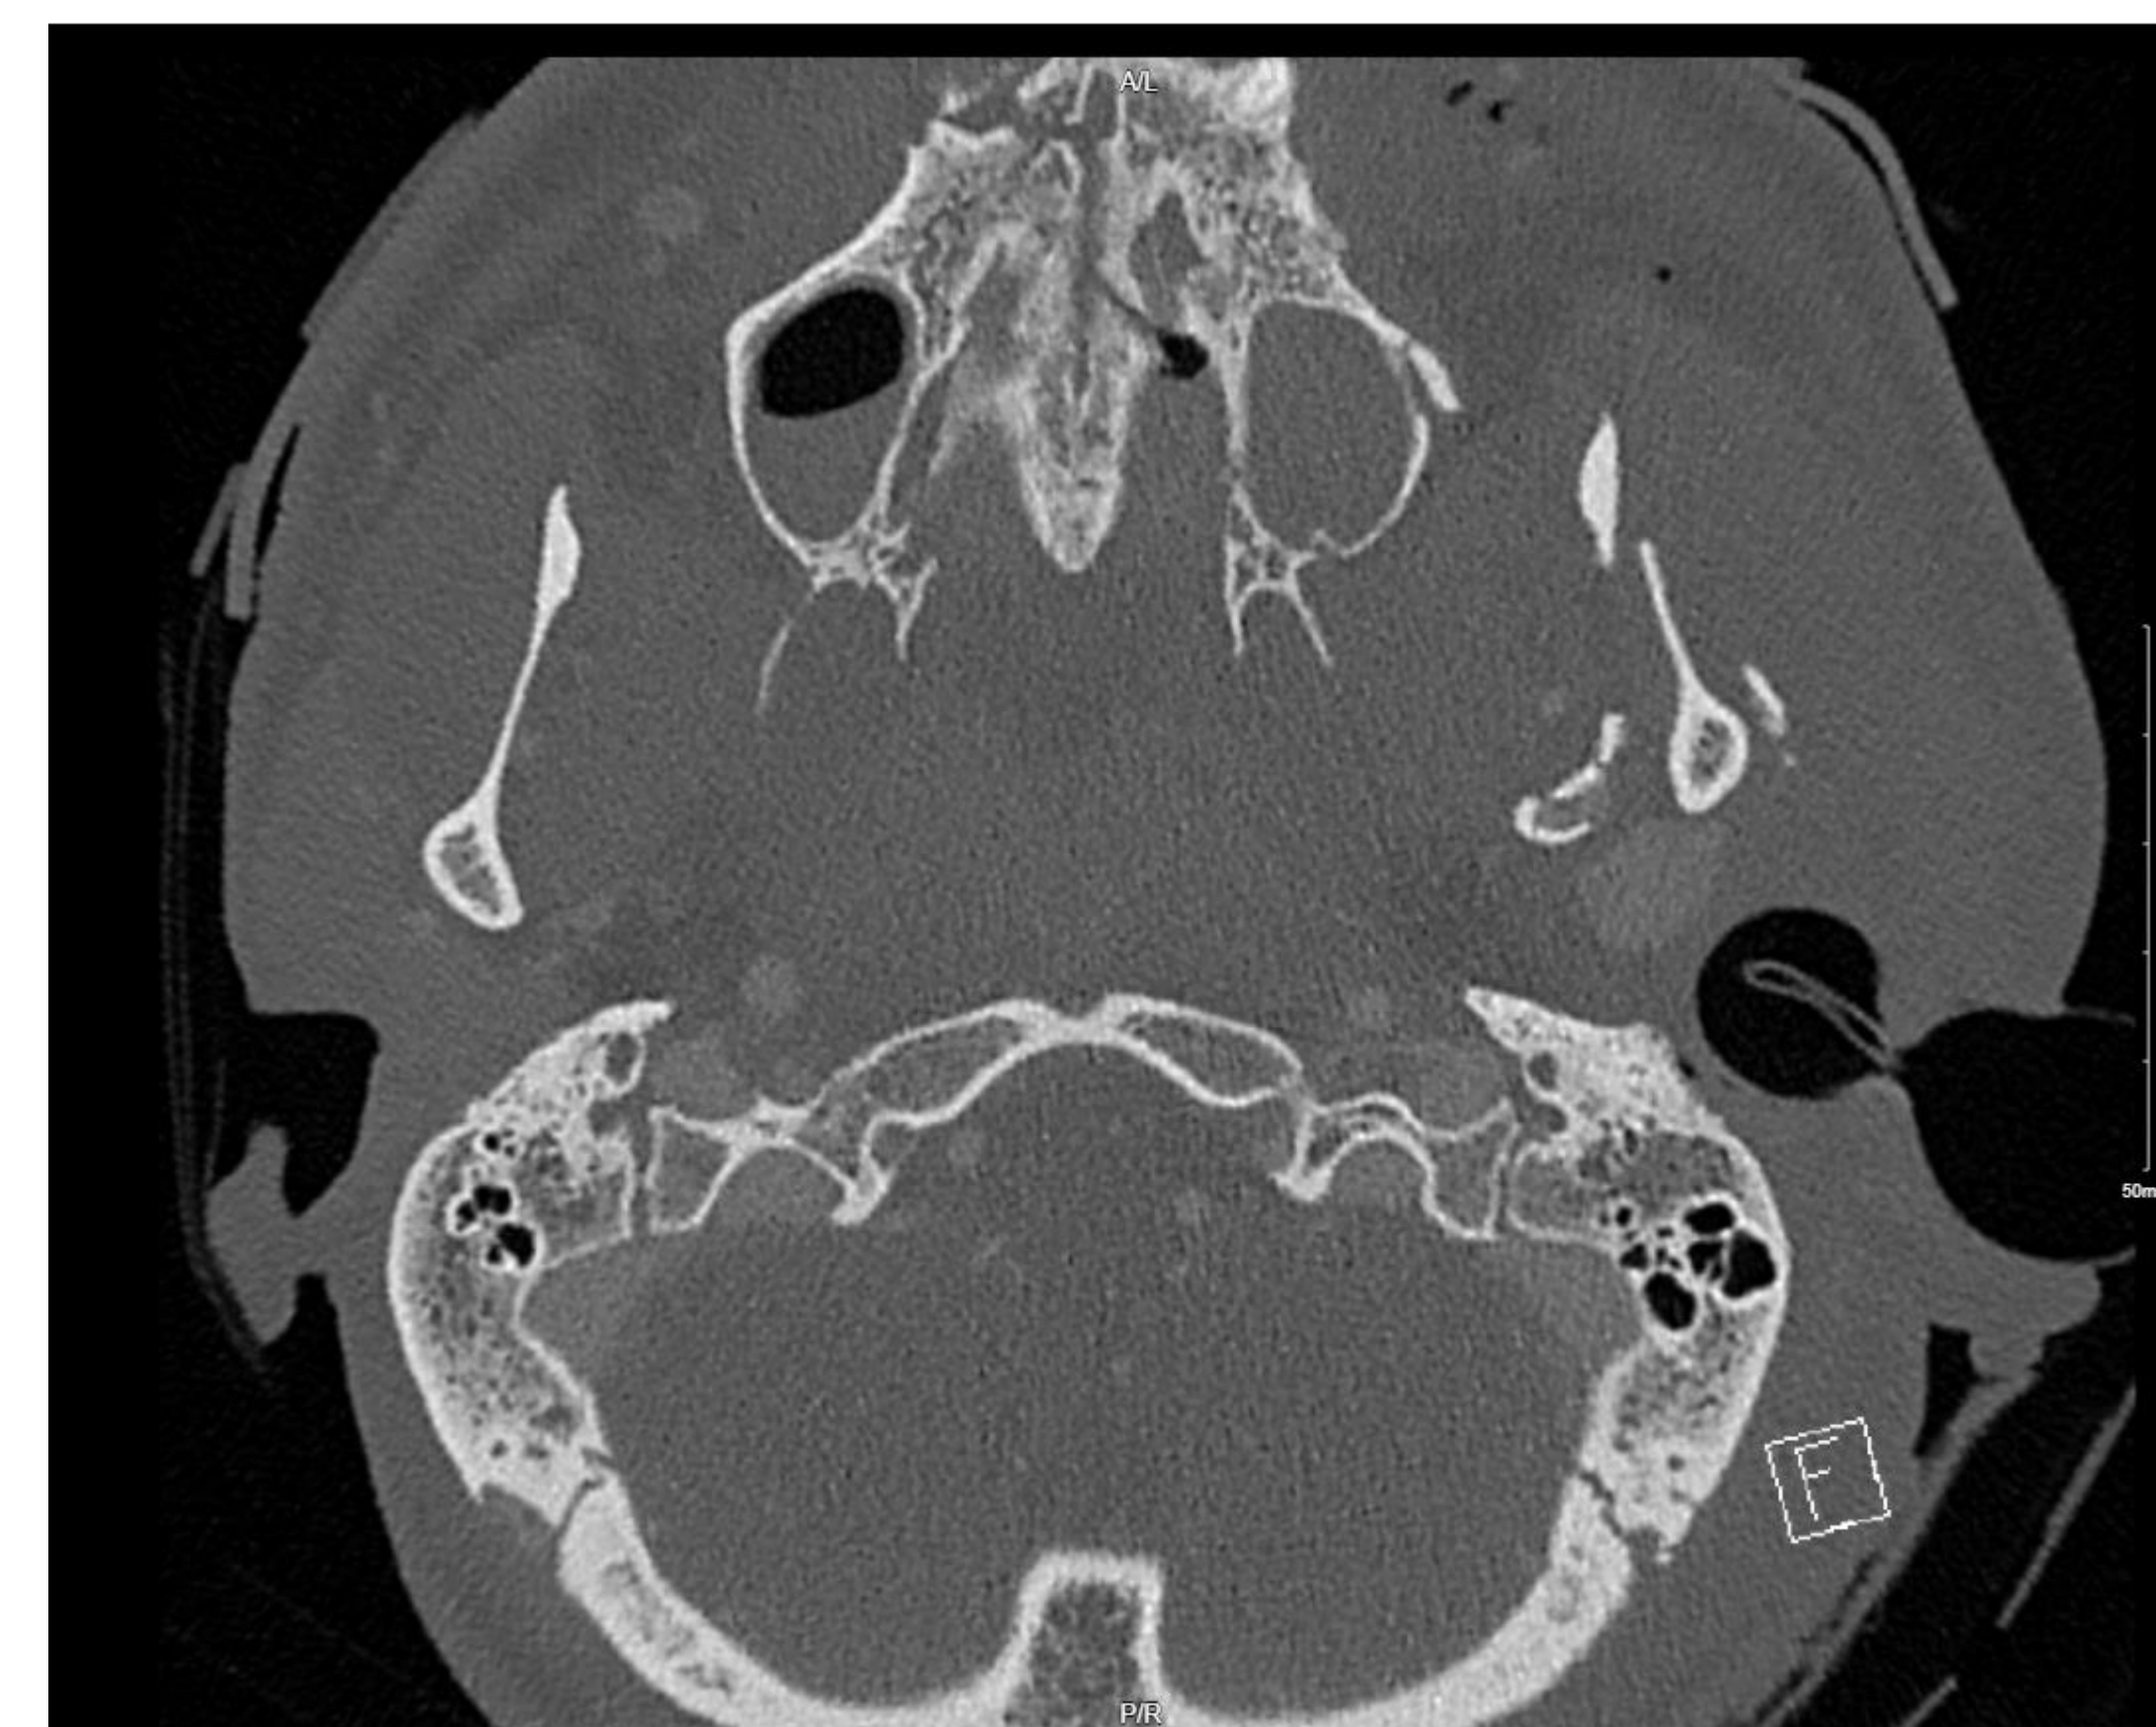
Axial CT Imaging (Obtained on admission)
